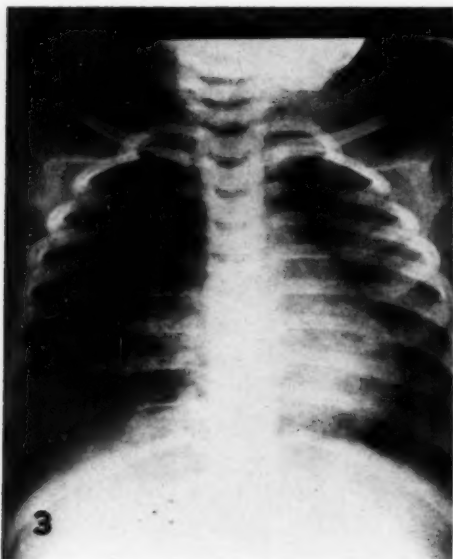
Radiograph taken one hour after an 11-month-old child drank kerosene. Child was dyspneic and slightly cyanotic. Changes are confined to basal segments of left lower lobe.
